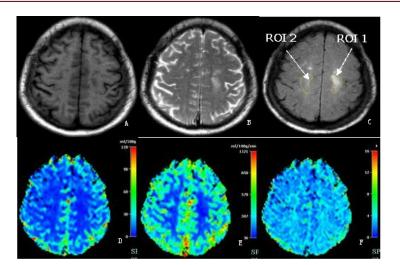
MRI and perfusion-weighted imaging scans from a 78-year-old man with dysarthria and right extremity weakness.
